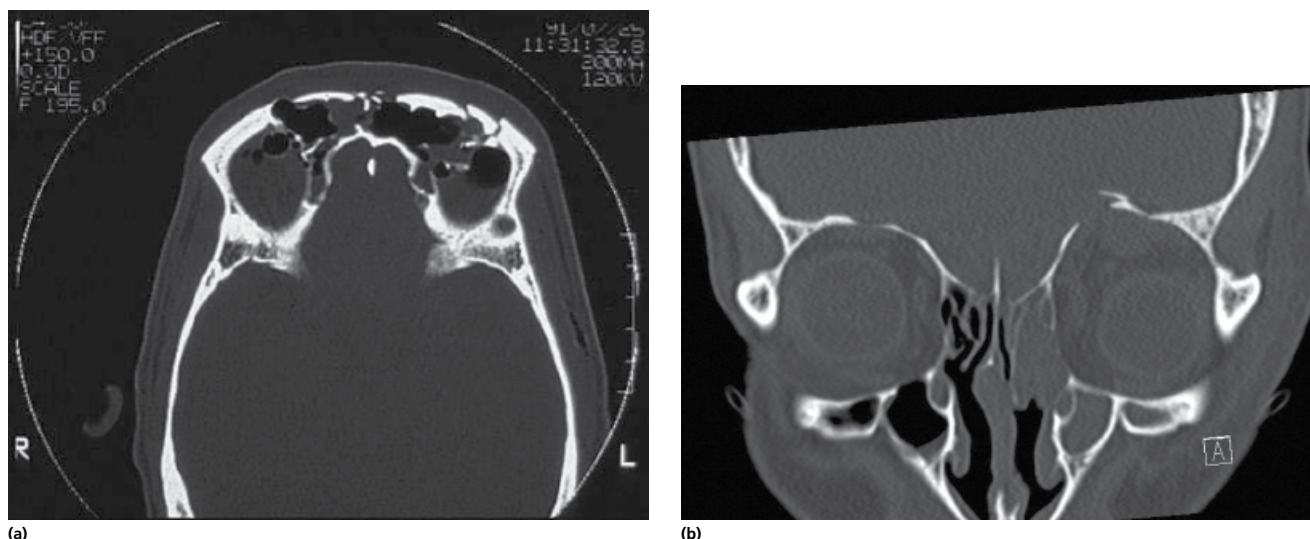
(a) CT scan showing a depressed comminuted fracture of the frontal sinus affecting both inner and outer tables resulting from blunt trauma. (b) A fracture of the orbital roof resulting from a billiard cue entering the orbit, sparing the globe, and penetrating the orbital part of the frontal bone and brain.
